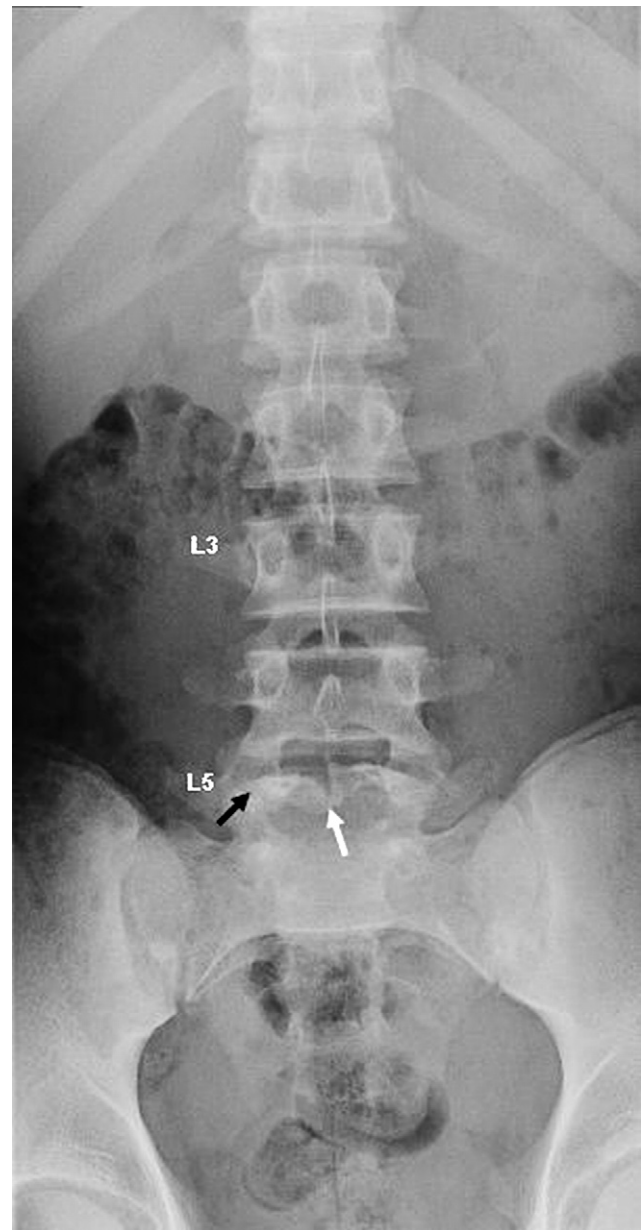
Anteroposterior lumbar spine X-ray showing pars interarticularis defect (black arrow) and spina bifida occulta (white arrow) at L5.
